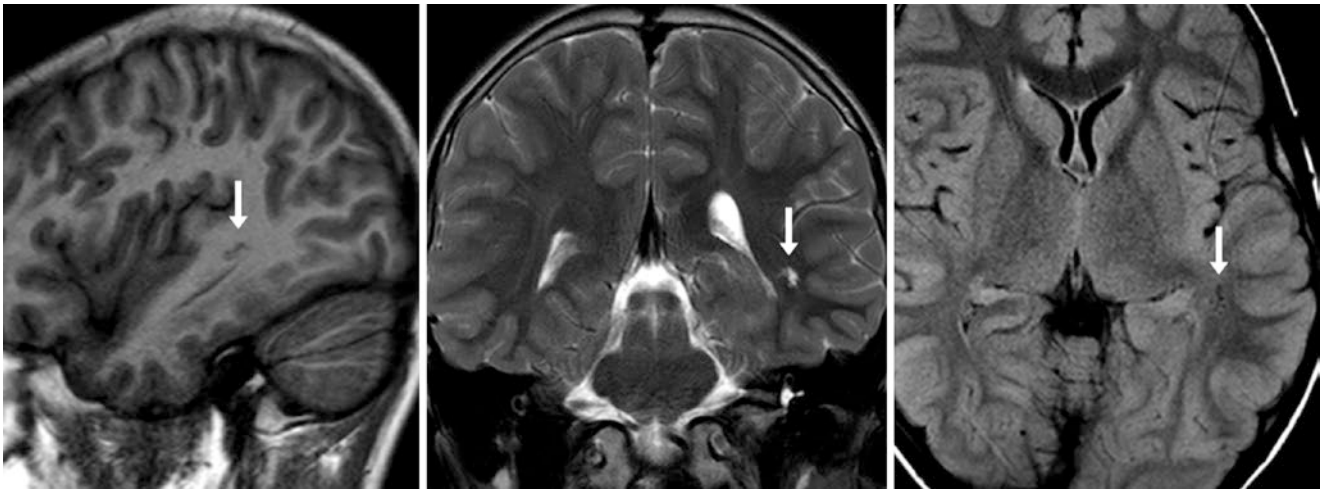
A 10 year old with headaches had a dilated PVS (*arrows*) of the left temporal lobe near the left lateral ventricle on sagittal T1WI (*left*) and coronal T2WI (*middle*). There was no white matter atrophy next to the ventricle, given the lack of hyperintensity around the PVS on FLAIR (*right*). Thus, this did not represent gliosis or leukomalacia
